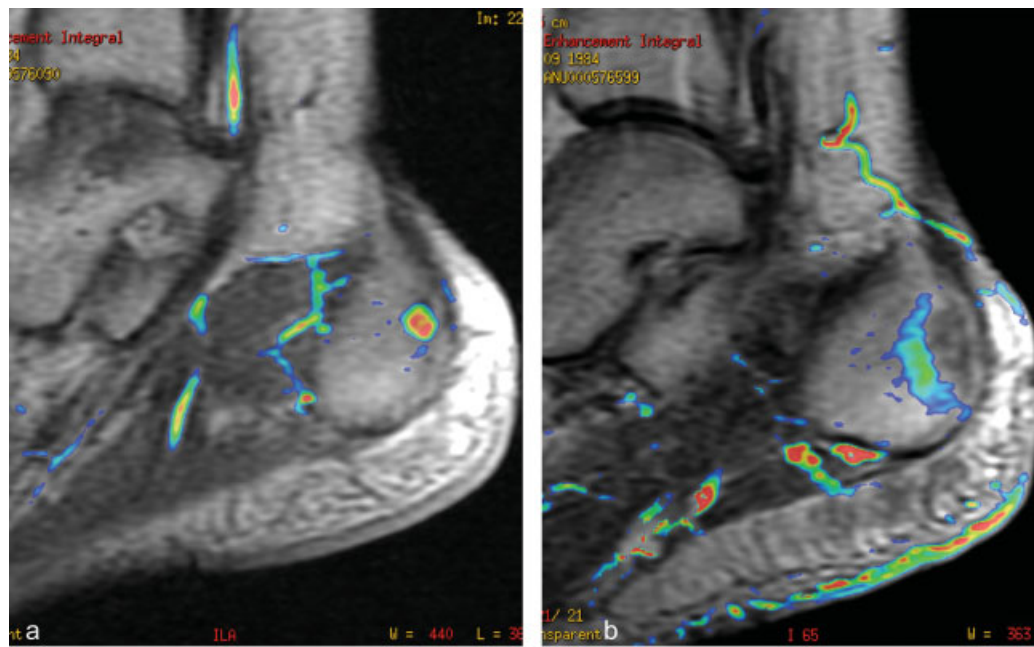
(a) Preprocedural dynamic contrast-enhanced MRI showing an osteoid osteoma on the calcaneus of a 21-year-old woman suffering from considerable pain (VAS = 8) and limitations to walking and other daily activities; the nidus is clearly identified as a highly vascularized focus (red) in the color map. (b) Dynamic contrast-enhanced MRI scan obtained immediately after treatment shows a complete suppression of nidus vascularity as expression of local tumor control; only a mild and vague local increase of vascularity can be seen in the surrounding region, as a normal result of postprocedural inflammation, which spontaneously resolved within days. This patient reported an immediate clinical benefit as well (VAS = 2 on the very first day after treatment, which turned to 0 at 1 week and remained stable during our 3-year follow-up period).
